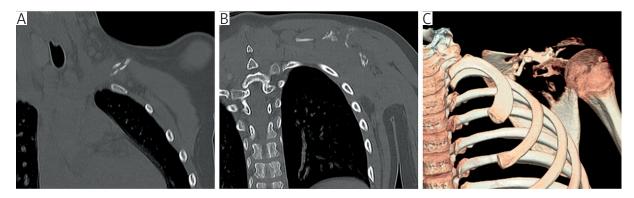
Left shoulder computed tomography (CT) scan, coronal multiplanar reconstruction (MPR). Massive osteolysis and fragmentation of the clavicle (A) and scapula (B). 3-dimensional (3D) reconstruction (C)
